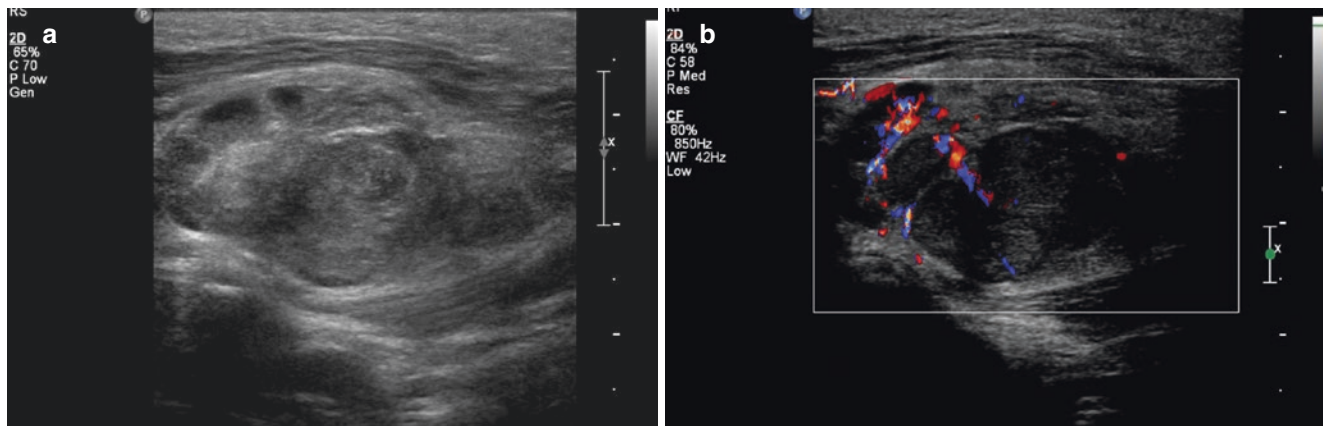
Necrotic lymph node mass. (a) Ultrasound image demonstrates a heterogeneous, conglomerate lymph node mass with liquefaction. (b) Colour Doppler image shows peripheral vascularity
